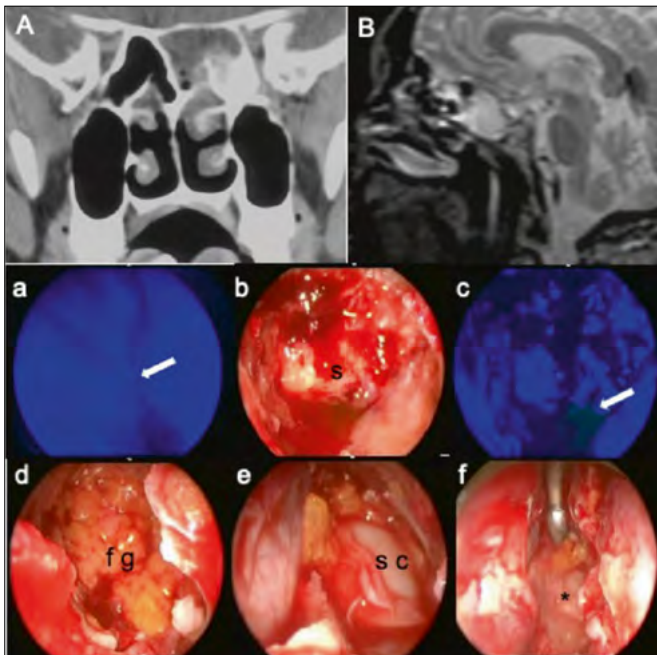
Coronal CT scan (A) and sagittal (B) T2 weighted MRI showed the presence of sphenoiditis and erosion of the clivus in a 54-year-old male patient with rhinorrhea 2 years after chemoradiotherapy for a nasopharyngeal cancer. The precise site of leakage was uncertain at the imaging so we used intrathecal fluorescein for a precise localization. The endoscopic pictures show fluorescein coming out from the sphenoid ostium (a) and after sphenodotomy the transudation of the liquor (b, c) through the clivus and below the sella (S). An obliterative technique (d) was preferred using an autologous fat graft (fg), a cartilage graft of the nasal septum (e) in a gasket seal way on the sphenodotomy, and fibrin glue (*).
